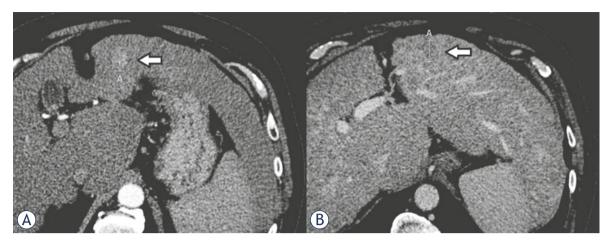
A 66- year-old male with hepatocellular carcinoma (HCC). Control CT after drug-eluting bead doxorubicin transarterial chemoembolization (DEBDOX TACE) and microwave ablation (MWA) shows non-target progression in segment III, 18 mm the largest diameter. (A) Hypervascular lesion in arterial phase. (B) Washout in venous phase.
